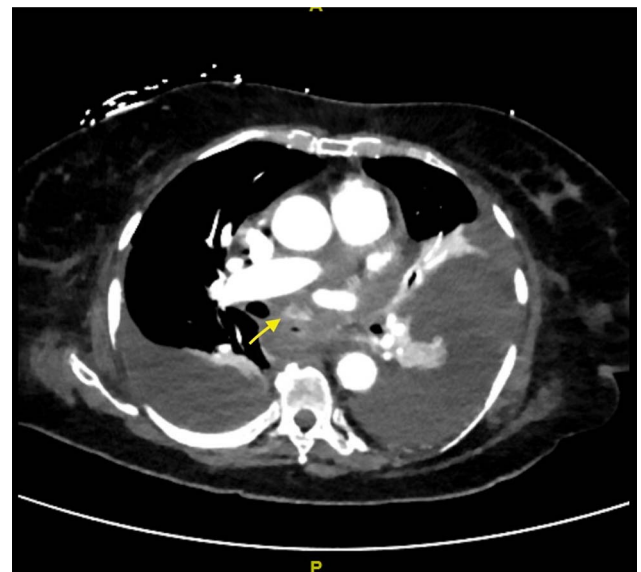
Chest computed tomography angiography with arterial blush of contrast.
